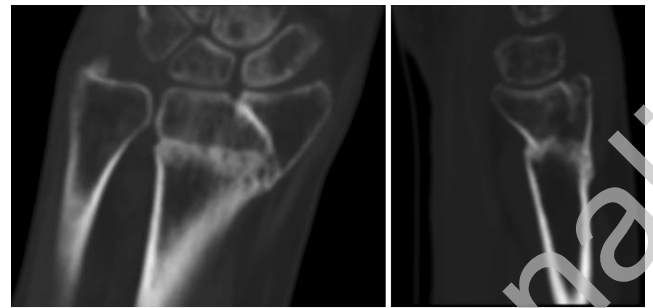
CT scan after 60 days of treatment.
